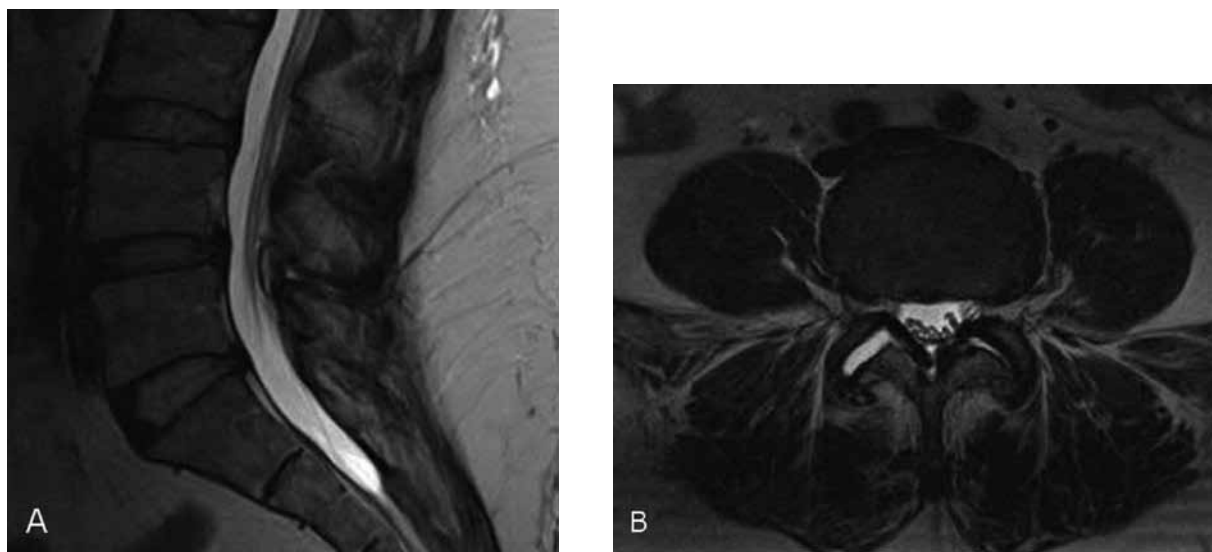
T2-weighted lumbar MRI. (A) Sagittal view—small cyst appreciated along the dorsal epidural space at the L4-5 level. (B) Axial view—increased fluid in the right L4-5 facet with subtle apparent connection with dorsal epidural space via a defect in the ligamentum flavum.
